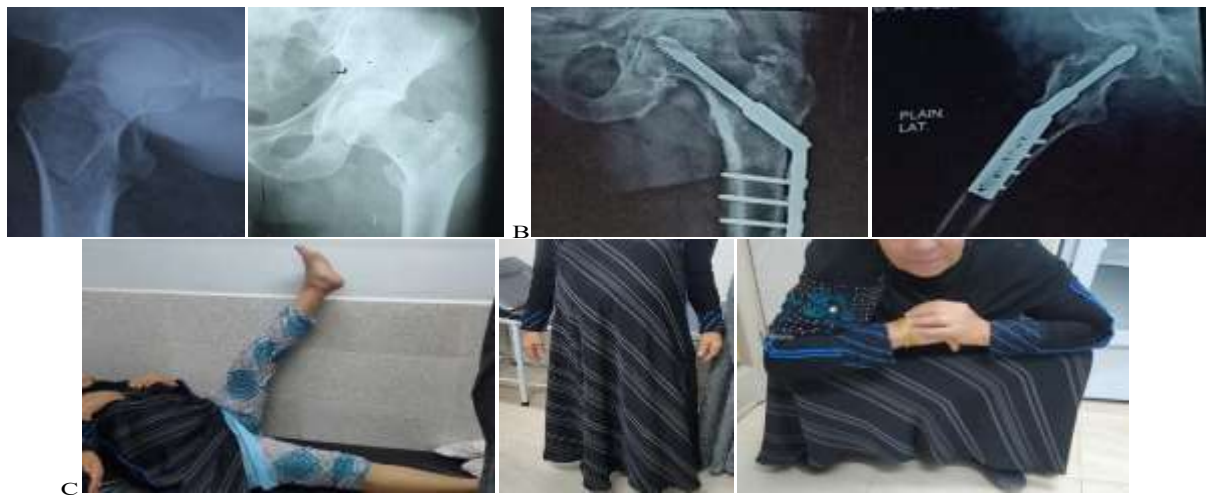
A female patient aged 58 years old with a history of slip and fall on the ground was presented to the ER and after examination, she was found to have an intertrochanteric fracture of the left side classification was 31, A1.1 according to AO classification with history of controlled bronchial asthma. The patient was operated on 3 days after admission. The patient was placed supine on a radiolucent traction table to allow for an image intensifier. The operative time was 70 minutes. 4 hole non-locked DHS plate with anti-rotation was used to fix the fracture. Post-operative IV antibiotics were administered for 3 days followed by oral antibiotics for 7 days. Union was noticed 3 months postoperative. Using the Harris Hip score for hip fracture, the patient had excellent function with a total score of 99 points. A) Preoperative X-rays. B) Follow-up x-rays at 6 months showing union. C) Functional outcome Active SLR and range of motion at six-month follow-up
